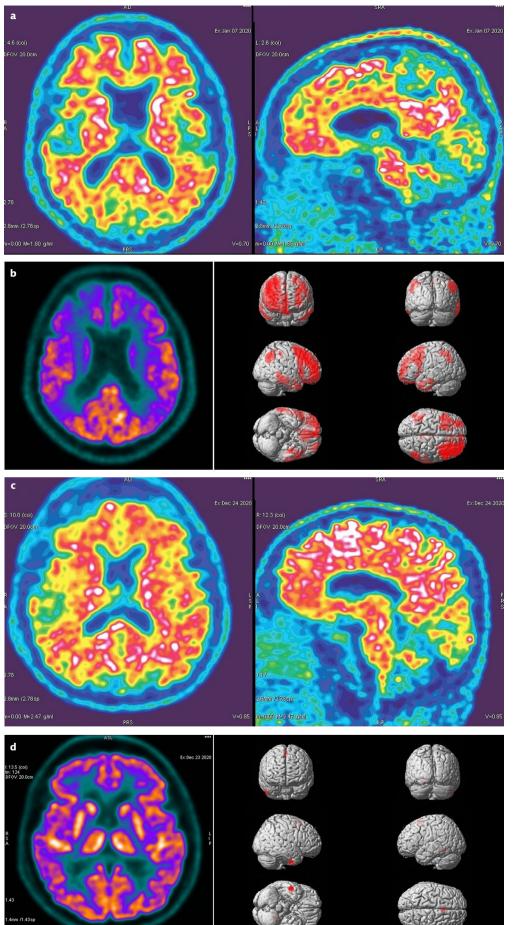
a-d Comparative [18F]flutemetamol and [18F] fluorodeoxyglucose PET images of two mild cognitive impairment (MCI) patients with different clinical courses. In case 1, a 68-year-old male university graduate, standardized mini mental test score (MMSE): 29, enhanced cued recall (ECR) test score: 46 (memory test, N>42) at the time of PET/ MR imaging (a and b) were obtained. [18F] flutemetamol PET imaging of this patient showed intense amyloid beta tracer retention in the brain (a). [18F] fluorodeoxyglucose PET imaging revealed significant glucose hypometabolism in the posterior cingulate cortex and bilateral parietotemporal cortices (b). These findings are seen both in the visual evaluation of PET and in the quantitative analysis performed with the statistical parametric mapping (SPM) method. In the SPM analysis, the brain PET image normalized to the patient's MNI atlas is compared with the normal [18F] fluorodeoxyglucose PET database, and areas with statistically significant hypometabolism are topographically shown on the brain MR image. In the clinical evaluation of this patient 2 years later, significant cognitive decline occurred, and the MMSE score was evaluated as 15. In case 2, a 64-year-old, university graduate male patient, when PET/MR images were obtained (c and d), his cognitive status was very similar to case 1 (MMSE score: 29, ECR score: 47). [18F]flutemetamol PET imaging of this patient showed overt amyloid beta tracer retention (c), and [18F]fluorodeoxyglucose PET imaging revealed normal glucose metabolism (d). No clinical regression (disease progression) was observed in the 2-year follow-up of case 2.
